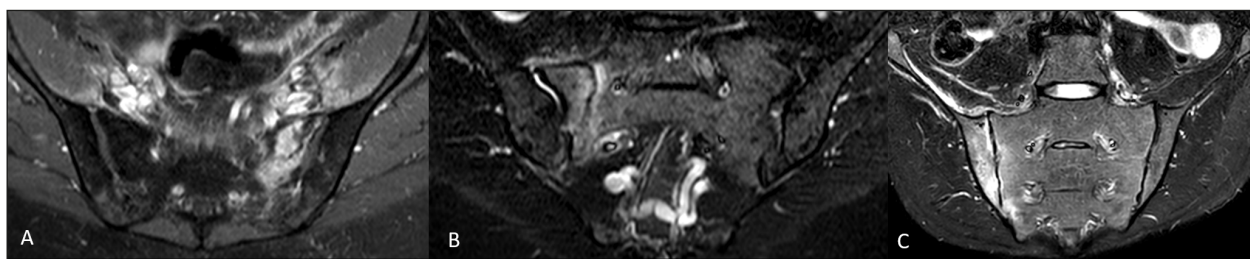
A) Axial fat-saturated T1-weighted post-gadolinium sequence showing hyperenhancement with hypointense vertical line in a 56-year-old patient with insufficiency fracture of the left sacral ala 9 months after external beam radiotherapy for cervical cancer; B) semi-coronal short tau inversion recovery (STIR) sequence showing bone marrow edema and vertical fracture at the right sacral ala in a 32-weeks pregnant 31-year-old woman; C) semi-coronal STIR sequence in a 28-year-old female patient with right septic sacroiliitis: bone marrow edema is unilateral and concurrent soft tissue edema is visible behind the iliac muscle.
